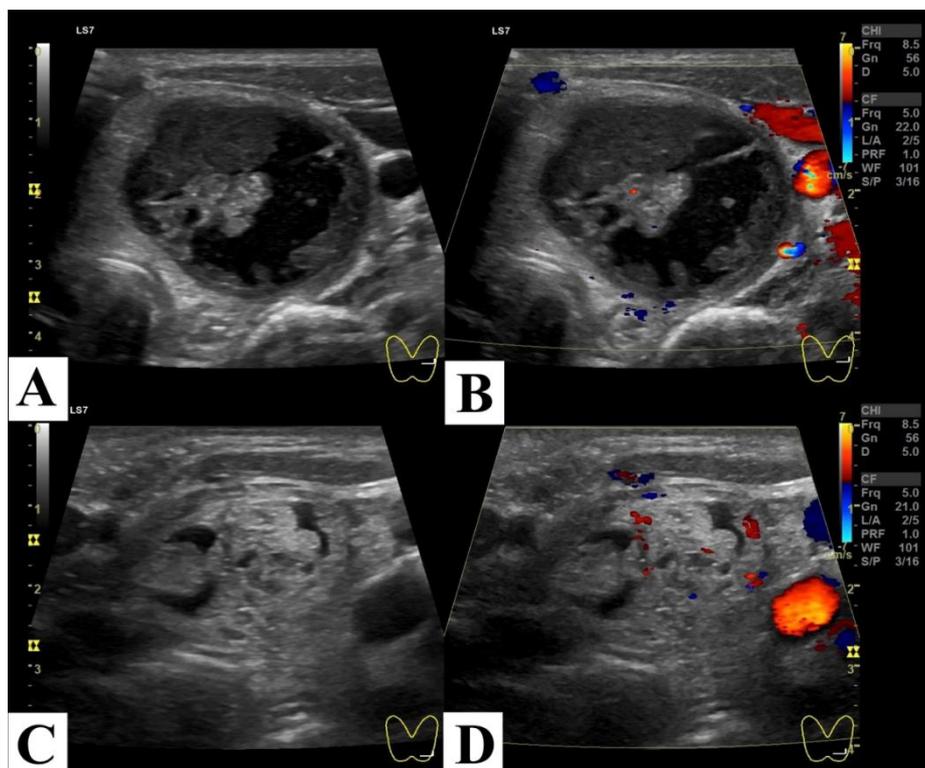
Ultrasound of thyroid gland (at initial admission)
